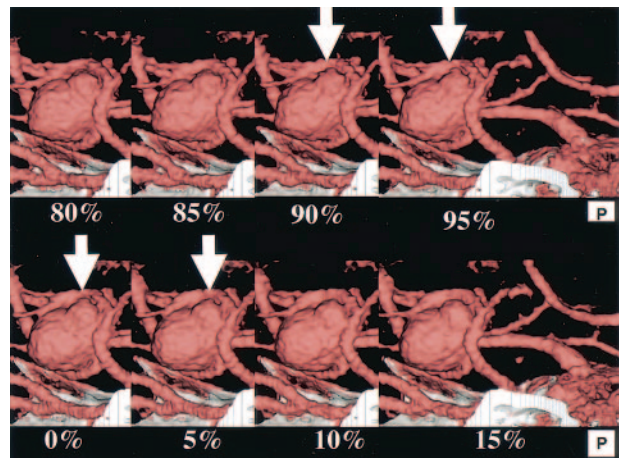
3D-CT angiography of intracranial aneurysm of the right MCA. The aneurysm with an associated bleb is seen at the origin of the right MCA (arrow).
